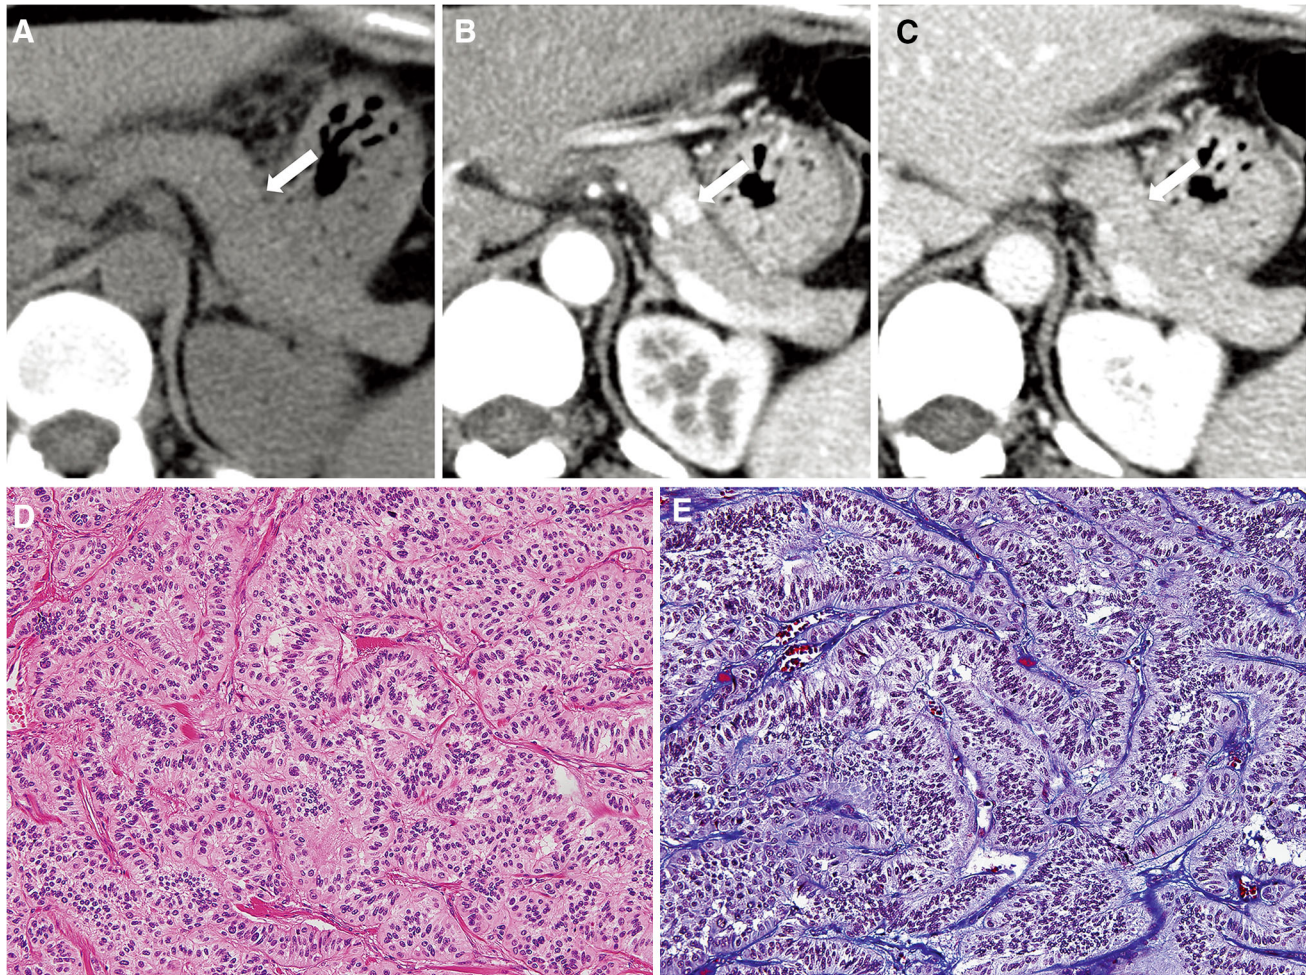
Pancreatic neuroendocrine tumor (grade 1) with an intratumoral fibrotic component in a 67-year-old female. (A–C) A 1.7-cm well-enhancing mass (arrows) is noted in the pancreas neck on dynamic CT images. The attenuation of this tumor was 41 HUs (A) on the unenhanced-phase image, 171 HU (B) on the arterial-phase image, and 222 HUs (C) on the portal venous-phase image, which shows a progressive enhancement pattern. A visible enhancement pattern is
